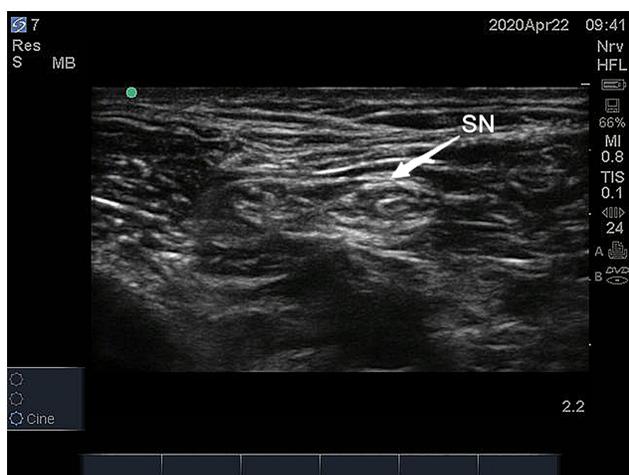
Sciatic nerve image under ultrasound scan. SN, sciatic nerve.
